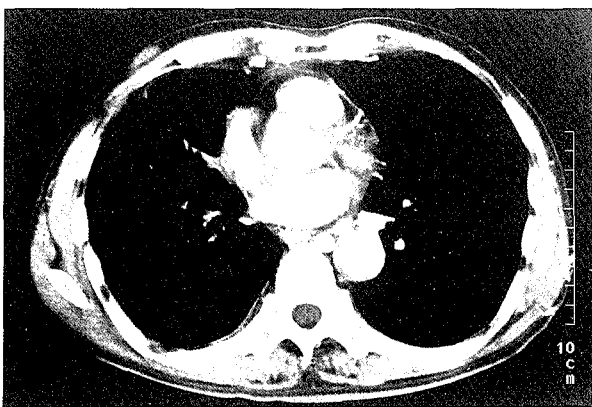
(Left) Chest CT scan revealing a mass lesion in the right atrium (before radiotherapy)
